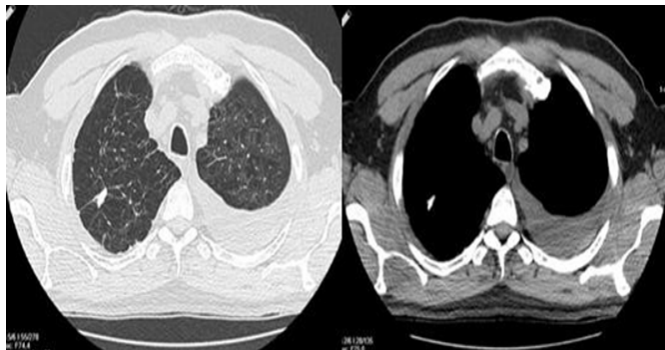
Computed tomography scan of the patient's chest
